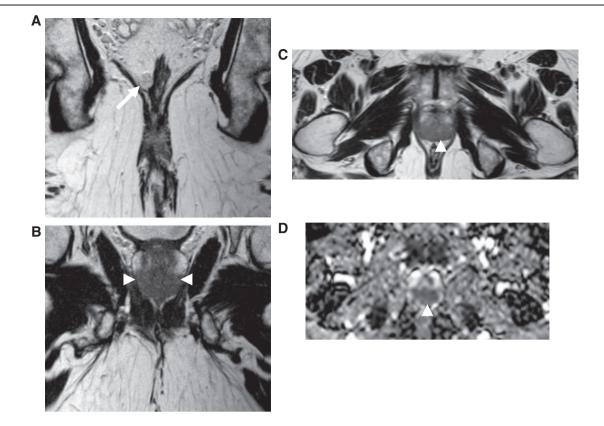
Incidental prostate cancer. A 62-year-old man was under surveillance following trans-anal endoscopic microsurgery (TEMS) for rectal polyps that had shown carcinoma in situ. A follow-up MRI was performed. The high-resolution coronal oblique T2-weighted images through the (a) rectum and (b) prostate and large field of view (c) T2-weighted images and (d) ADC maps through the pelvis show extra-mural recurrence (arrow) at the site of the TEMS but also show a focal lesion in the prostate with restricted diffusions (arrowhead) suspicious of prostate cancer. Prostate biopsy confirmed prostate cancer (Gleason 4+3).
